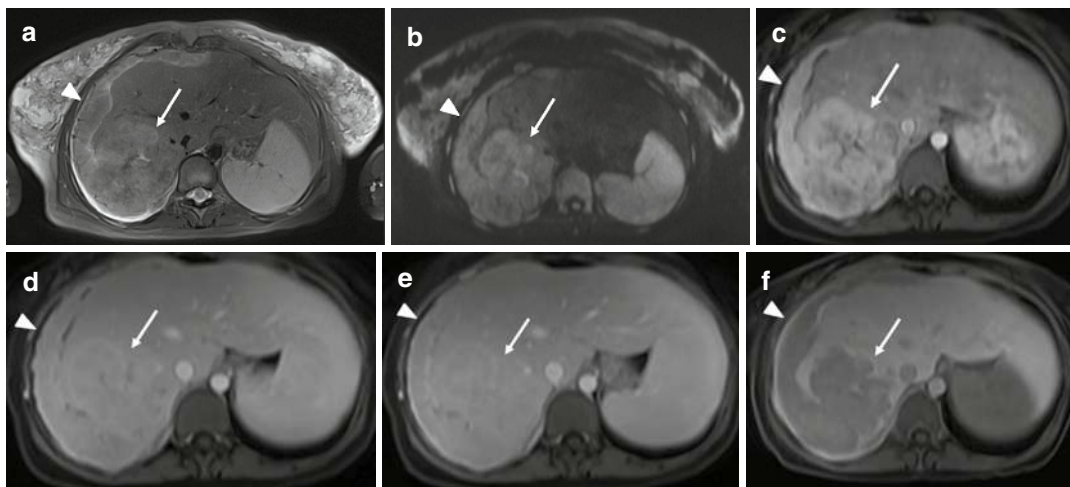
A 26-year-old female with fibrolamellar carcinoma. (a, b) Axial T2-weighted MRI showed a well-defined lobulated heterogeneously hyperintense lesion (arrow) with a central hypointense scar in the liver with similar appearing soft tissue deposits along the hepatic surface; both the lesion and deposits showed diffusion restriction on diffusion-weighted
